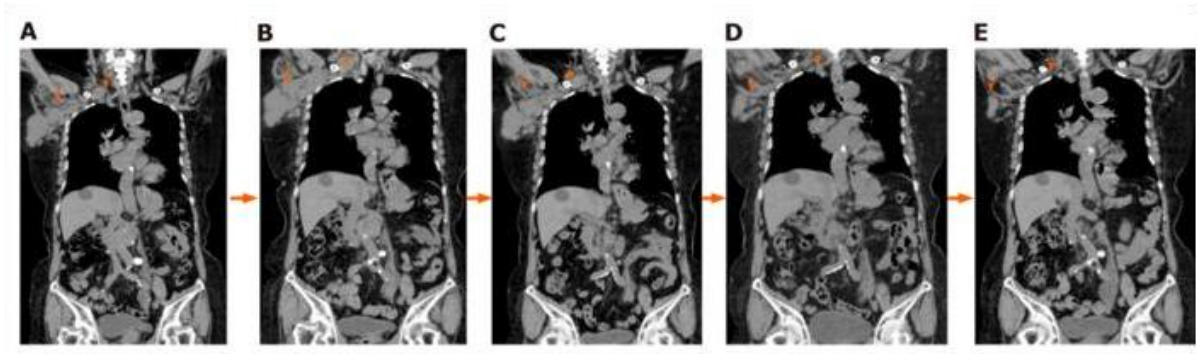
CT imaging findings before and after treatment of a case of HABA with smoldering ATL.
